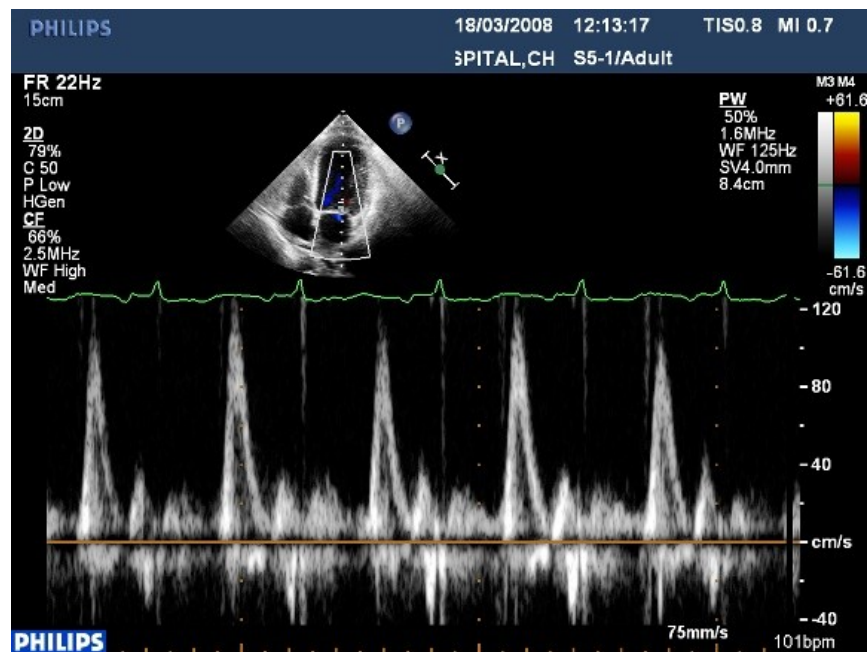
Pulsed wave Doppler echo of mitral inflow showing restrictive filling pattern in a patient with AWTMI who developed Cardiogenic Shock
